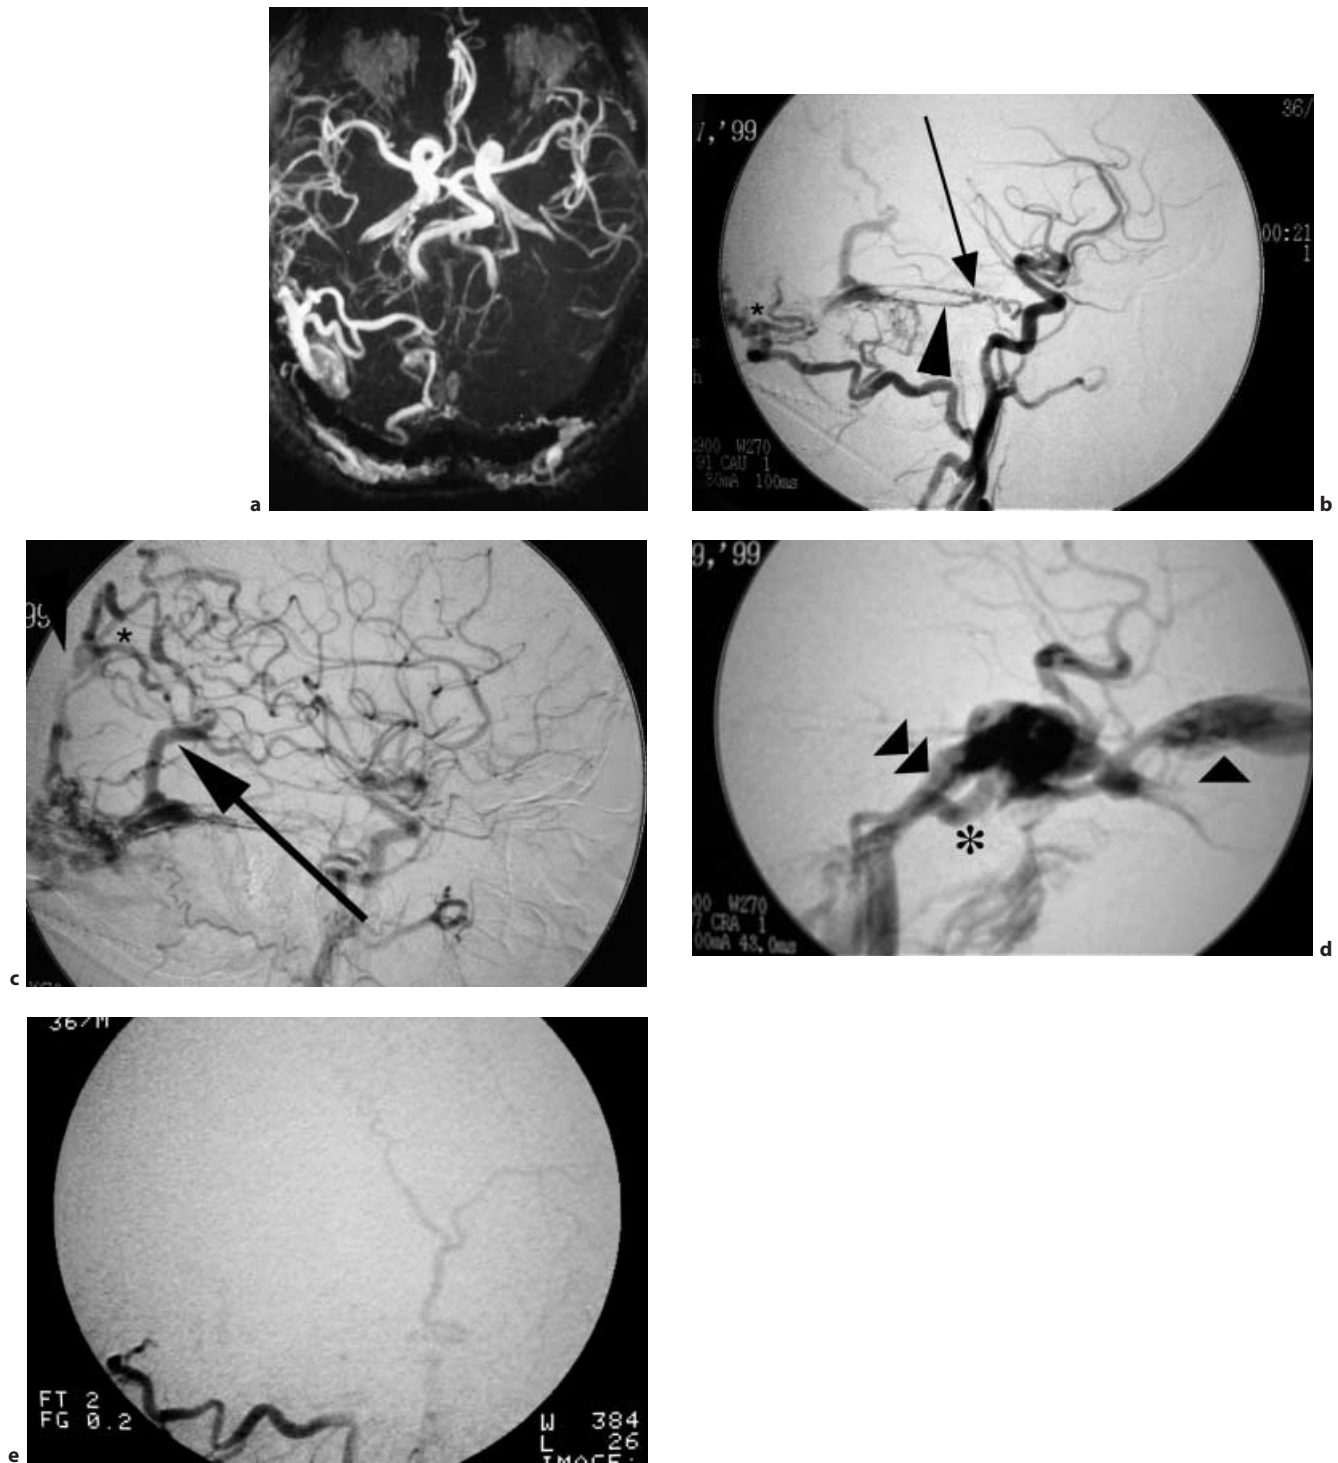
a A 55-year-old man presenting with headache and seizure. No history of parenchymal hemorrhage. MRI congested veins over right hemisphere, occluded right transverse sinus. b Digital subtraction angiography (DSA) in the lateral view shows external carotid artery (ECA) supply from occipital artery (*asterisk*), middle meningeal artery (*arrowhead*) and meningohypophyseal trunk (*arrow*) from ICA. c, d Lateral view in the early and late venous phase from carotid injection, with retrograde opacification of cerebral veins overlying the right occipital and posterior parietal lobes (*arrow* and *asterisk*). This degree of parenchymal venous opacification constitutes a high risk of cerebral hemorrhage or infarction. The right transverse sinus is occluded and a large vein of Labbe demonstrates retrograde filling. Complete obliteration
